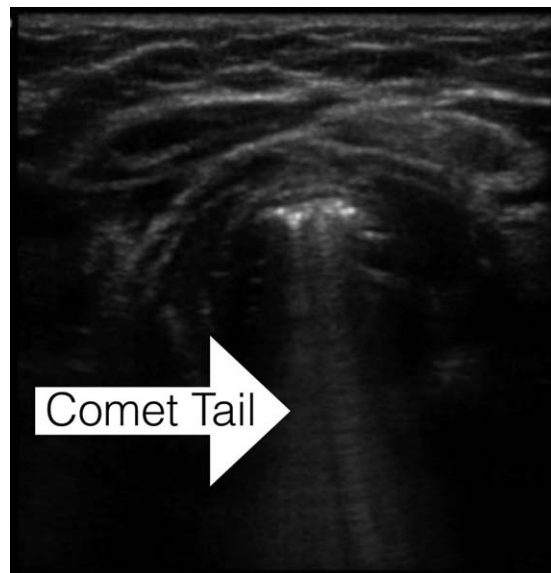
Sonogram showing a transverse view of the anterior trachea with the comet tail artifact emanating from the trachea, indicating that the endotracheal tube is in the correct position.
